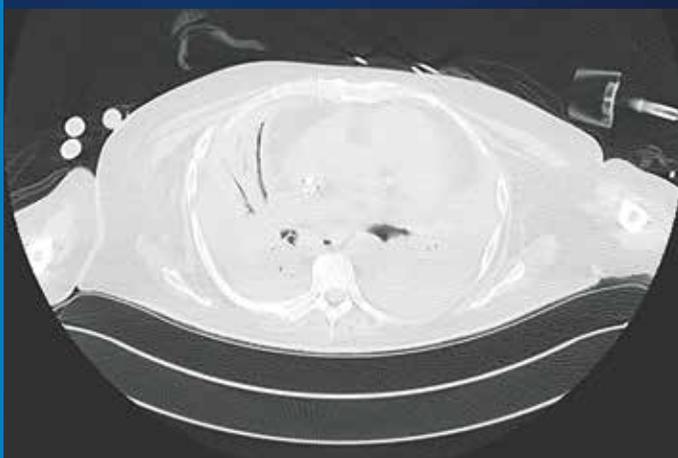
A chest CT taken a few days before transplantation shows densely consolidated lungs with air bronchograms, volume loss in the lungs and bilateral pleural effusions. Also seen is the dual-lumen ECLS cannula that courses through the superior vena cava and right atrium into the inferior vena cava.
